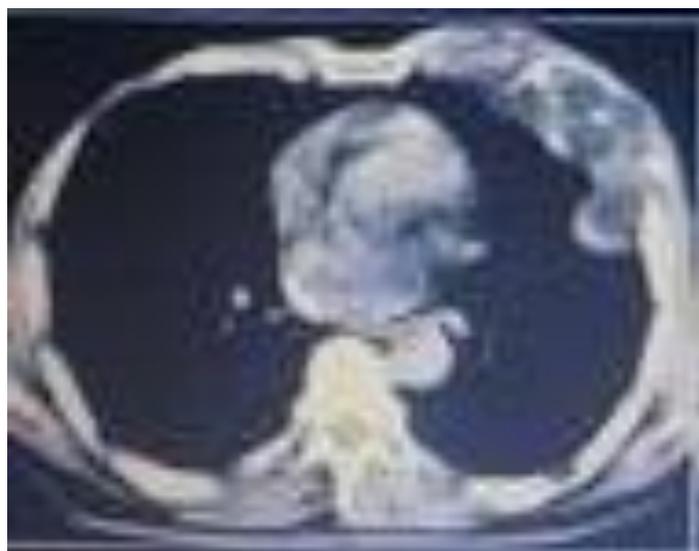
CT-Scan aspect multivesicular mass with osteolysis of the left 4th rib
